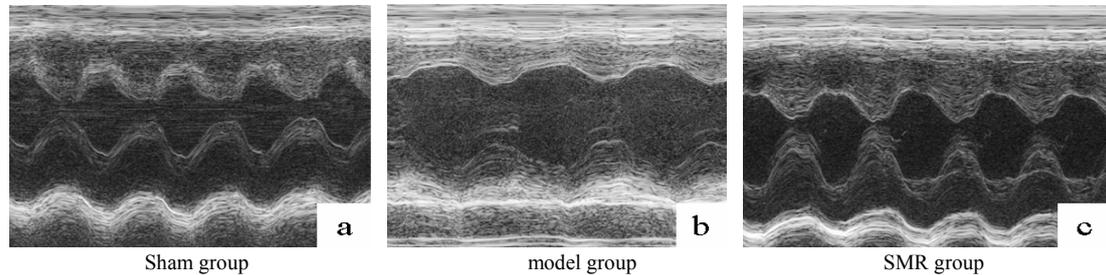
Representative M-mode echocardiograms
